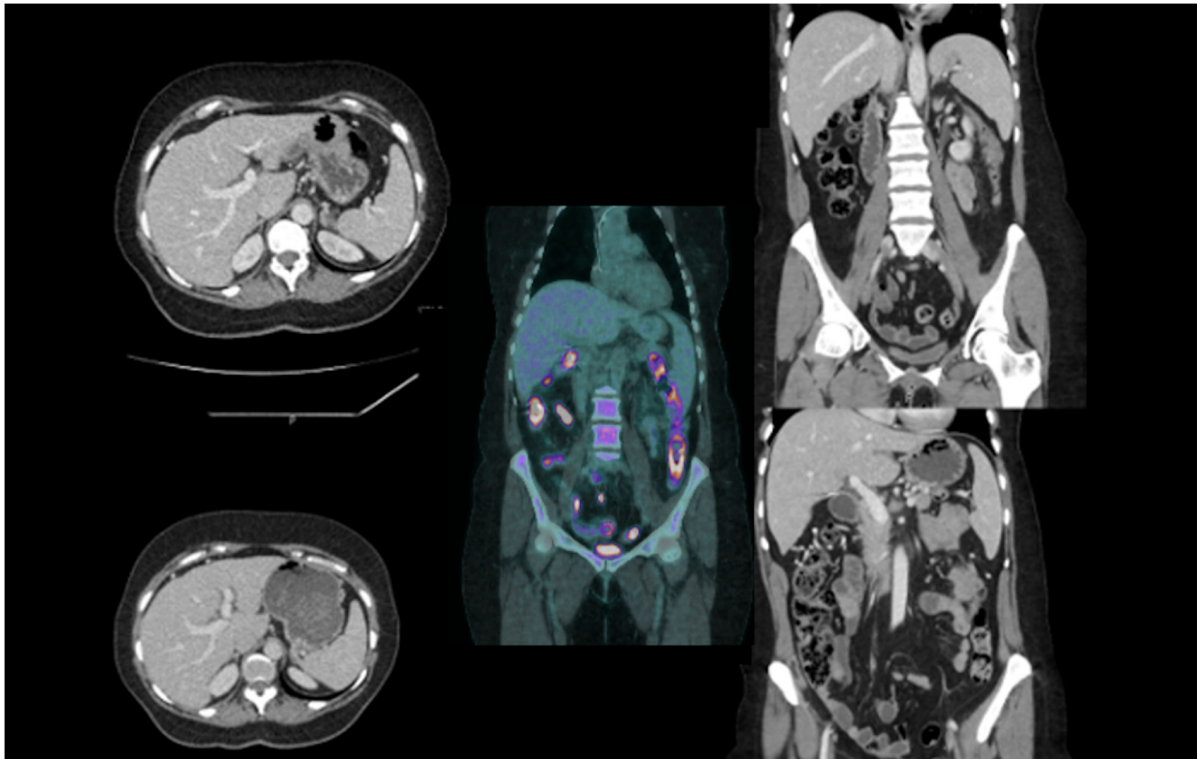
Sustained hepatic response on interval imaging and metabolic assessment (2021). Contrast-enhanced CT images demonstrating continued absence of radiologically detectable hepatic metastases. Left column: Two representative axial CT images obtained at different levels of the liver showing no focal hepatic lesions. Right column: Coronal contrast-enhanced CT reconstructions confirming sustained radiological response without evidence of metastatic disease. Centre panel: Whole-body FDG-PET (June 2021) demonstrating complete metabolic response with no abnormal hepatic FDG uptake.
